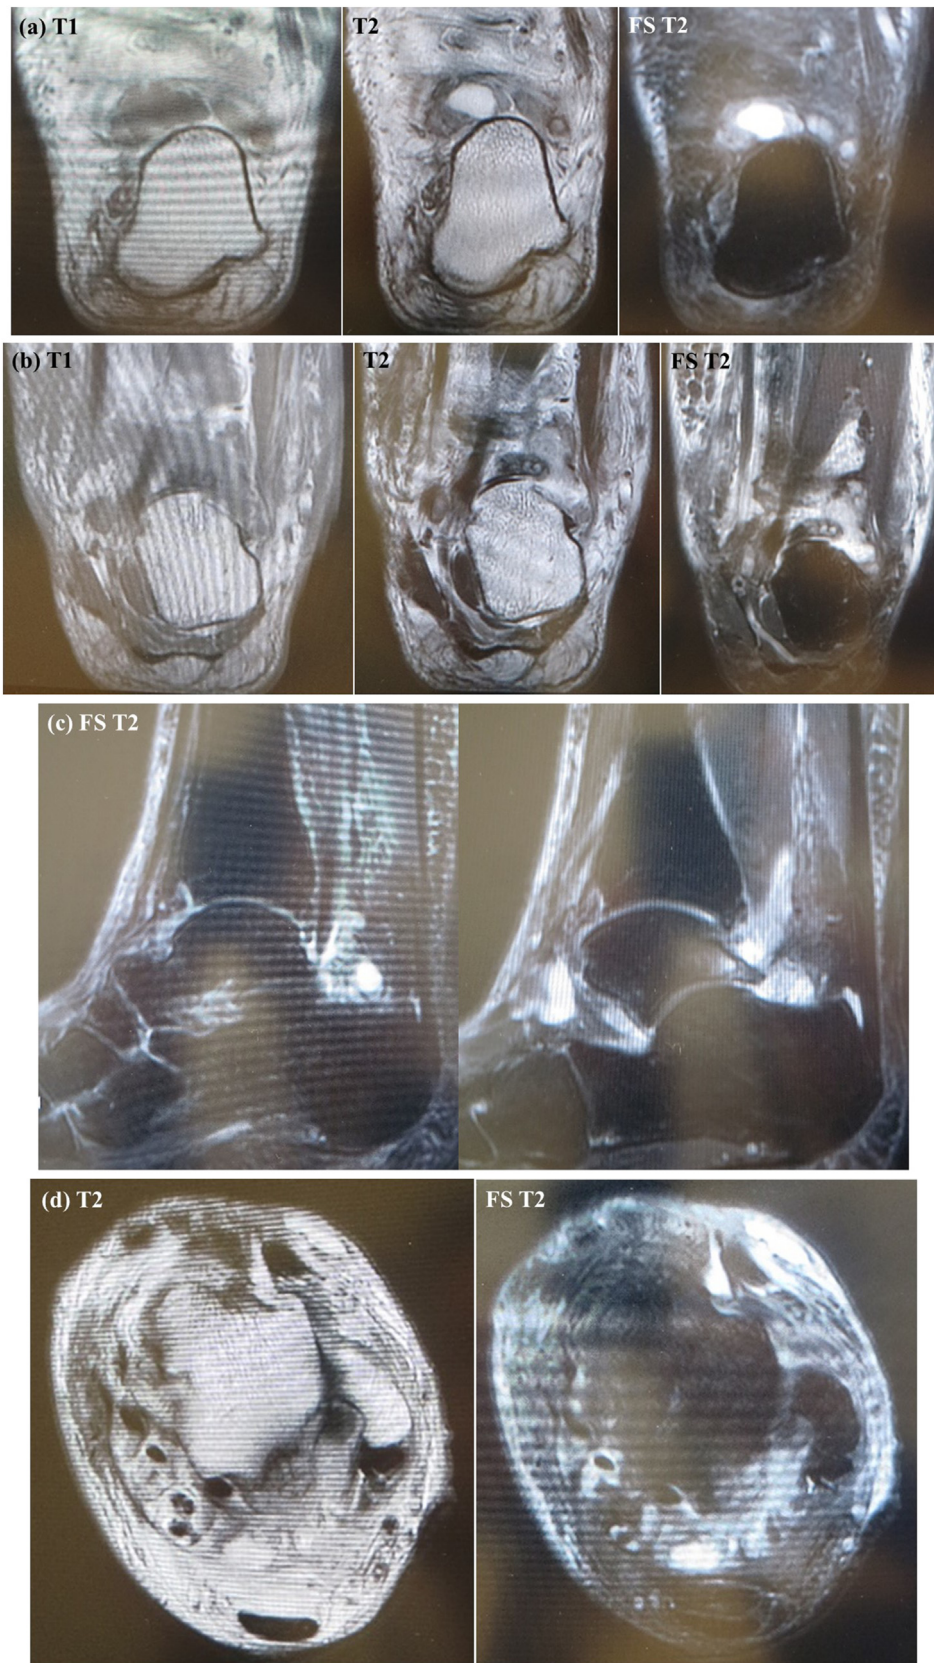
T1-weighted, T2-weighted, and FS T2-weighted magnetic resonance scans in the coronal plane (a, b), an FS T2-weighted scan in the sagittal plane (c), and T2-weighted and FS T2-weighted axial images (d) showing cysts and adjacent soft tissue edema-like signal intensity and bone marrow edema in the enlarged posterior talar process with synovitis in the posterior ankle.
